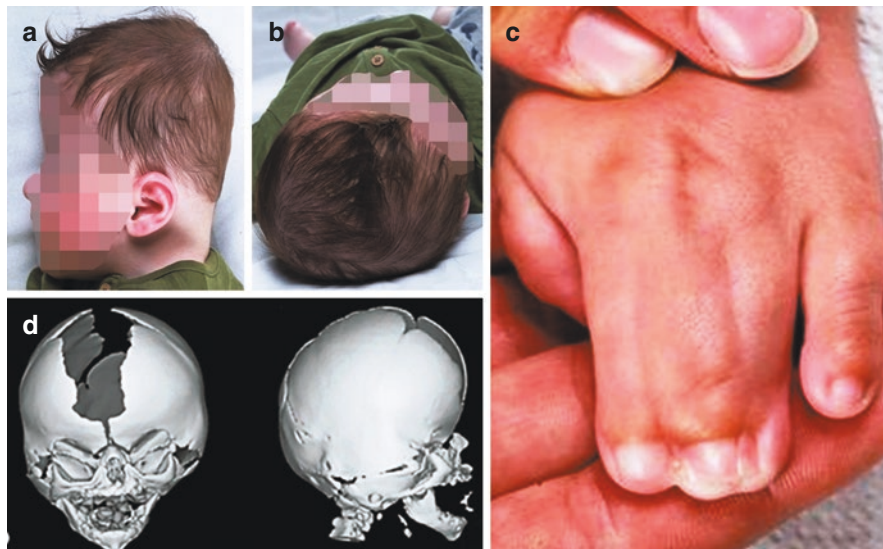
Apert syndrome. (a) lateral view of the head of an affected child; (b) superior view of the same patient's head; (c) hand digits' syndactyly; (d) 3D computed tomography (CT) reconstruction of the patient's skull (anterior and lateral view)
